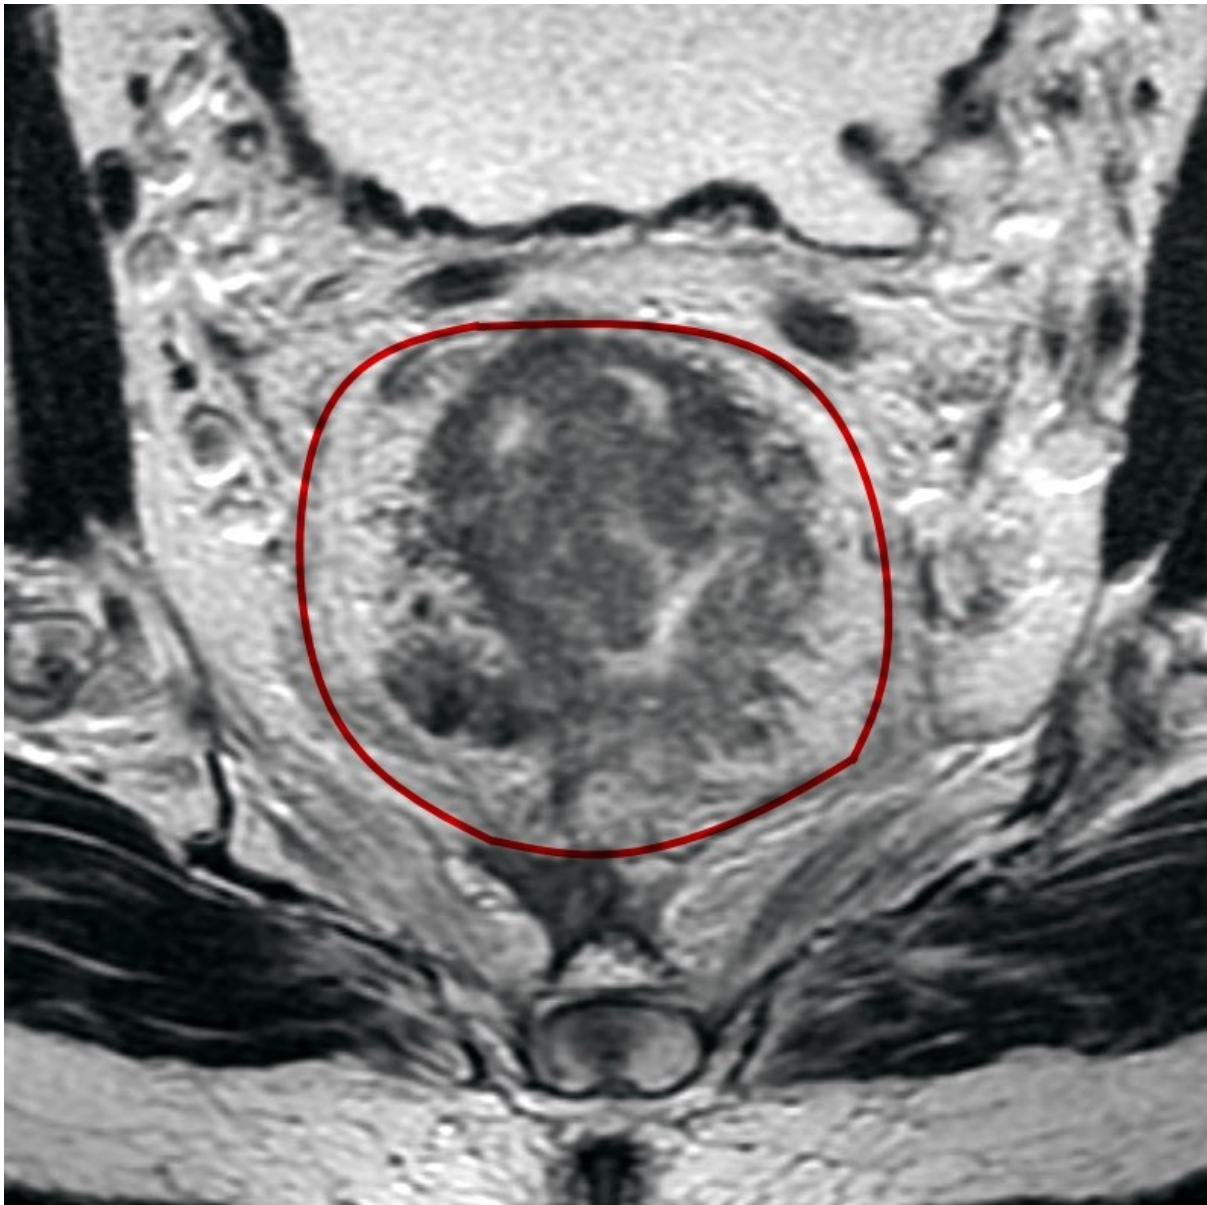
Circumferential resection margin as shown on high-resolution T2-weighted MRI
